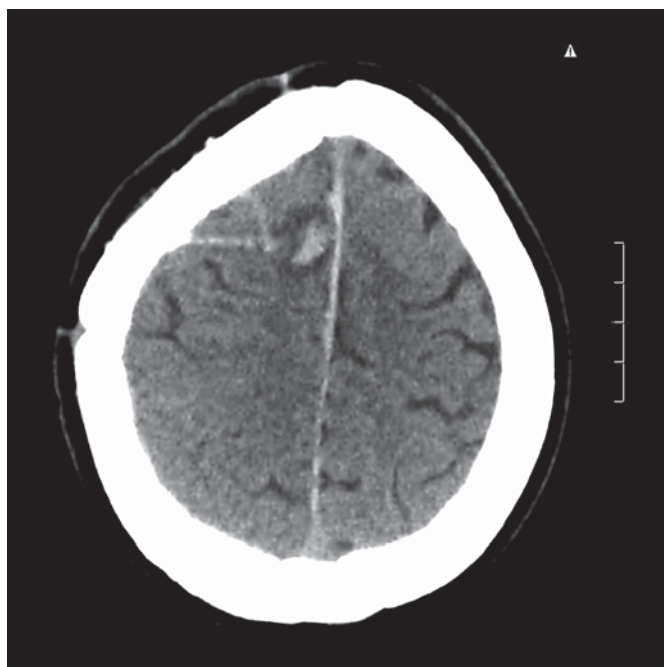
CT scan of the only hemorrhagic complication among the 1,130 implanted SEEG.
